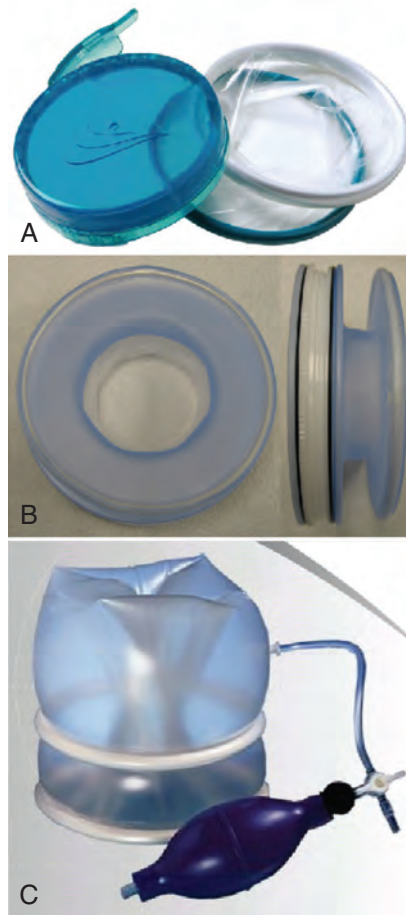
Hand port devices. A, GelPort. B, Lap Disc. C, Omniport. (Courtesy SurgiQuest, Milford, CT.)
